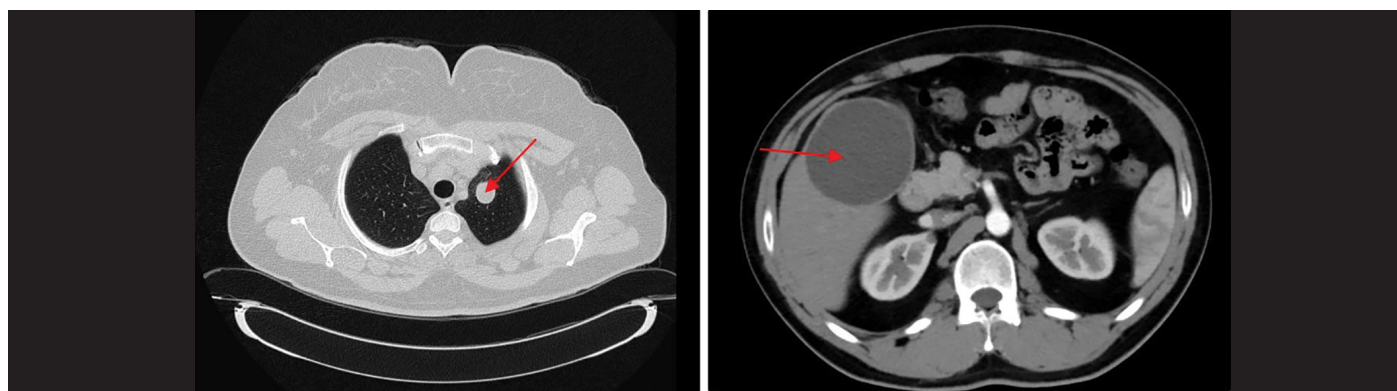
Cyst appearances on lung CT and abdominal CT in 2 different patients with positive *Echinococcus* IHA
